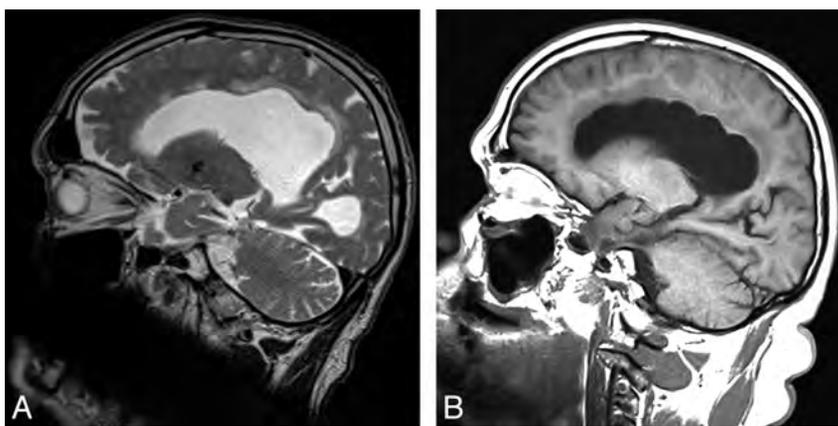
Two patients with focal bulging of the roof of the lateral ventricles. Sagittal images include the most cranial portions of the lateral ventricles. *A*, T2-weighted image. *B*, T1-weighted image.
